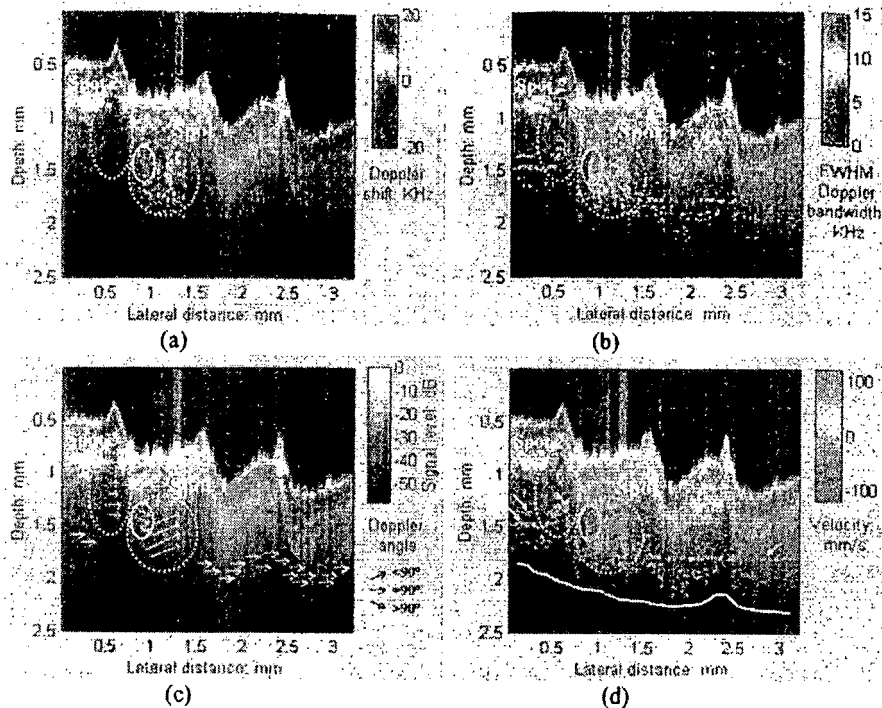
(a) Doppler shift image superimposed on a structural image taken from the pars villosa of the upper lip of a female volunteer. In spot 1, the two regions of blood flow are in opposite directions. (b) Doppler bandwidth image superimposed on structural image. The smaller flow spot 2 is not detected in (a). (c) Doppler angle mapping depicted based on the calculated values with Eq. (1), where the three flow regions in spots 1 and 2 are represented with arrows of different orientations. (d) Velocity mapping calculated by Doppler shift and estimated Doppler angle. Three flow regions in spots 1 and 2 are clearly identified.
